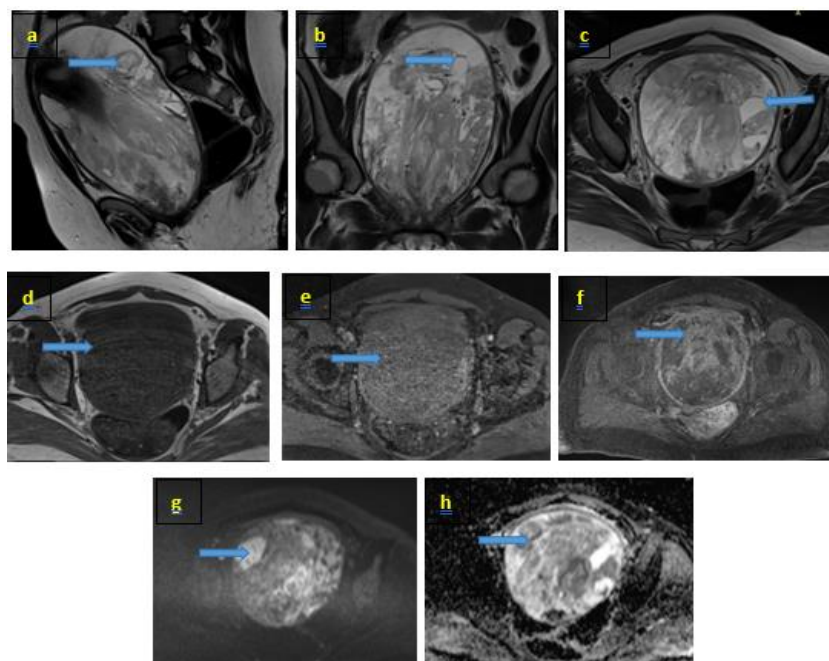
Bulky abdominopelvic mass, well-defined, encapsulated, centered on the cervicovaginal region. The lesion was heterogeneously hypointense on T1-weighted images [d] and intermediate signal intensity on T2-weighted images [a, b and c], with a cystic component and multiple septations [a, b and c]; Diffusion restriction [g, h] and an intense and heterogeneous enhancement was observed after gadolinium administration [e, f]
